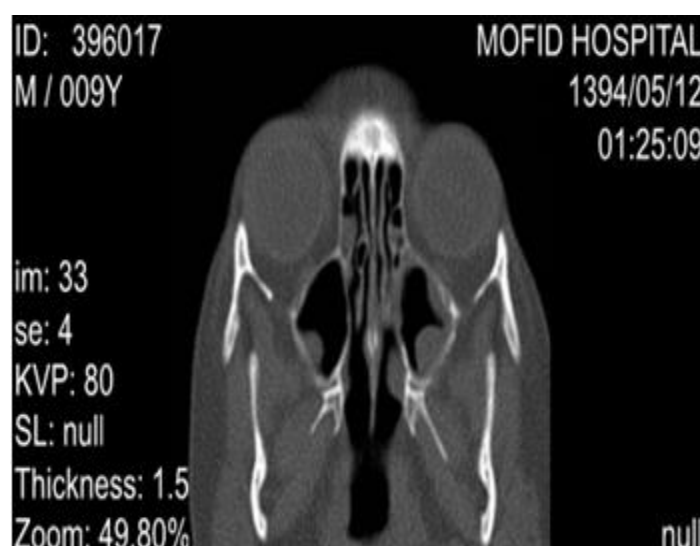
(case 1). Spiral CT scan of the Paranasal sinuses without IV contrast (axial view): Mucosal thickening of the bilateral ethmoid and maxillary sinuses with retention cysts in maxillary sinuses more on left side. Bilateral OMCS are obliterated.
